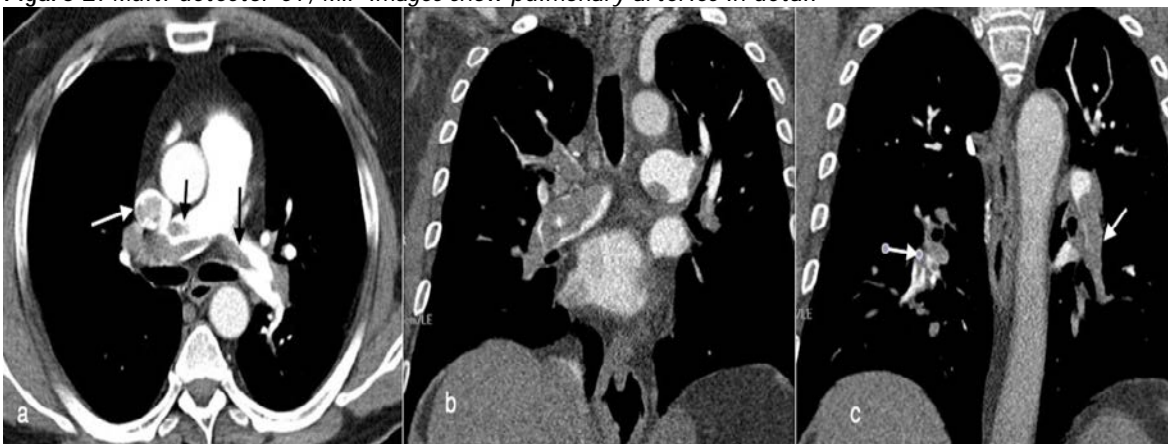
Acute massive pulmonary embolism on multi-detector CTA. a. There is filling defect due to thrombus in right and left pulmonary artery (black arrows) and v.cava superior on axial slice (white arrow); b. On coronal reformatted images, in right and left pulmonary artery; c. Filling defects due to thrombus in segmental and subsegmental branches of pulmonary artery (arrows)
